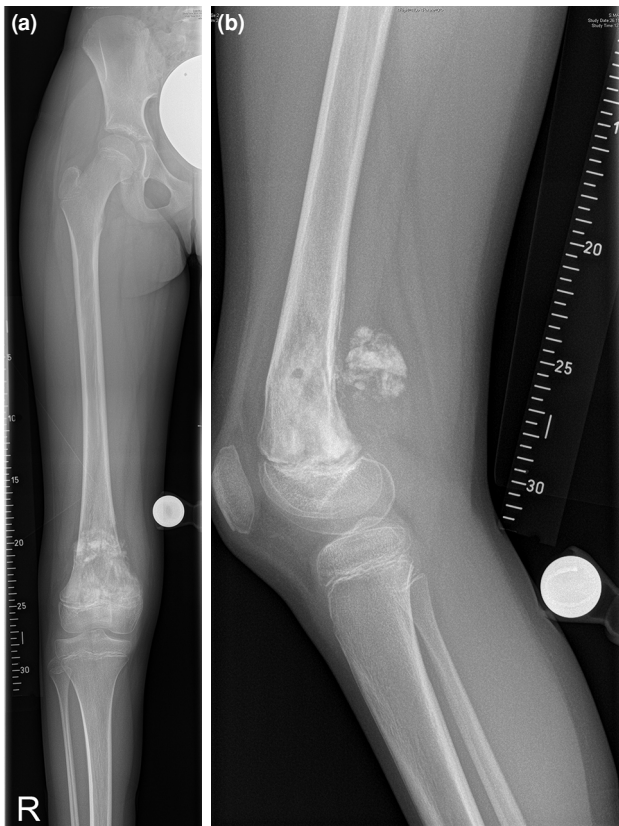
Ten-year-old girl with osteosarcoma of the right distal femur (a) preoperative anteroposterior radiograph (b) preoperative lateral radiograph.
